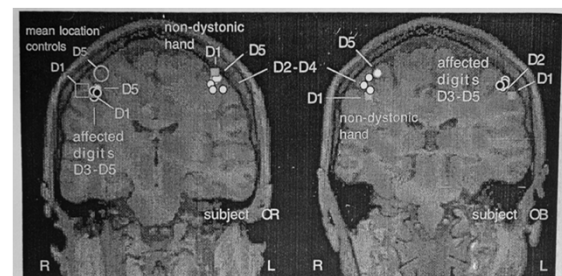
A coronal MRI section through the somatosensory cortices of 2 musicians (OR and OB) with focal hand dystonia onto which are projected the dipole locations of digits 1-5 (D1-D5) resulting from contralateral stimulation. The large open symbols in the right hemisphere of subject OR indicate the mean location of dipoles for D1 and D5 in normal control subjects.
